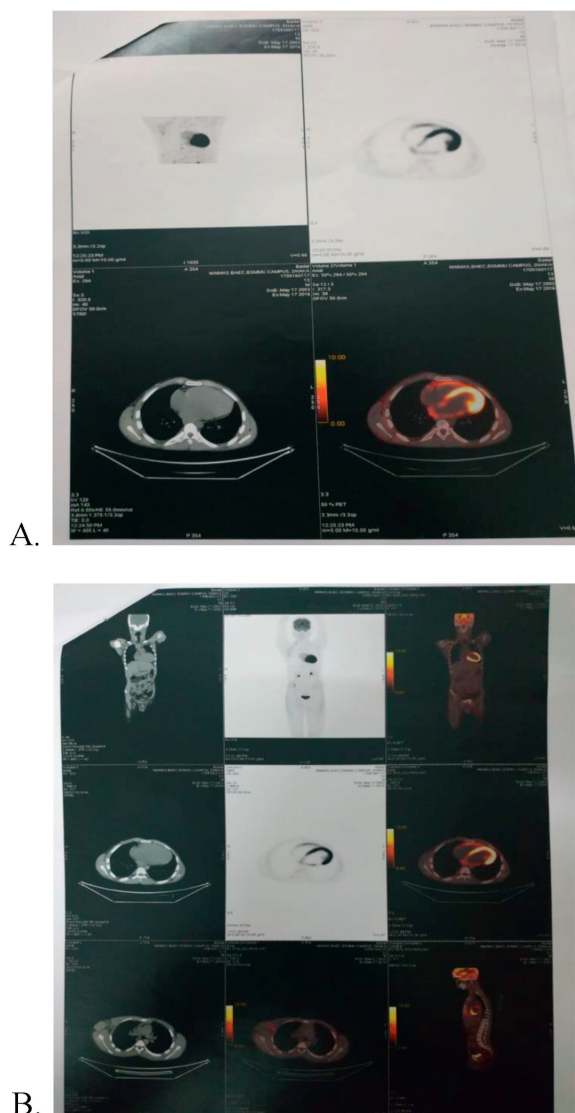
Whole Body F18 FDG PET-CT: A. Cardiomegaly with focal FDG avid within the left ventricular cavity likely to be prominent papillary muscle B. Numerous low FDG avid size significant lymph nodes in right side of neck, mediastinum and right axilla that suggest active stage of chronic granulomatous inflammation of lymph nodes.
